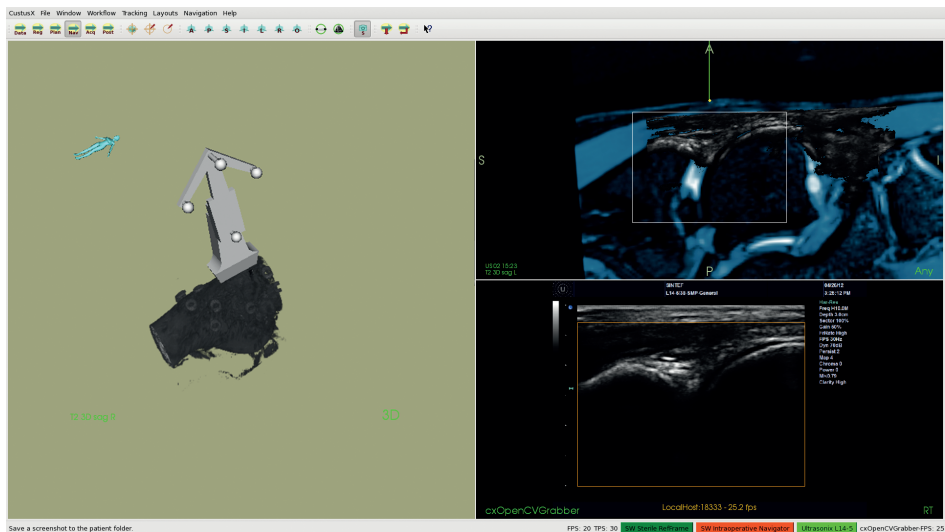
Location retrieval of ultrasound images using 3D tracking
